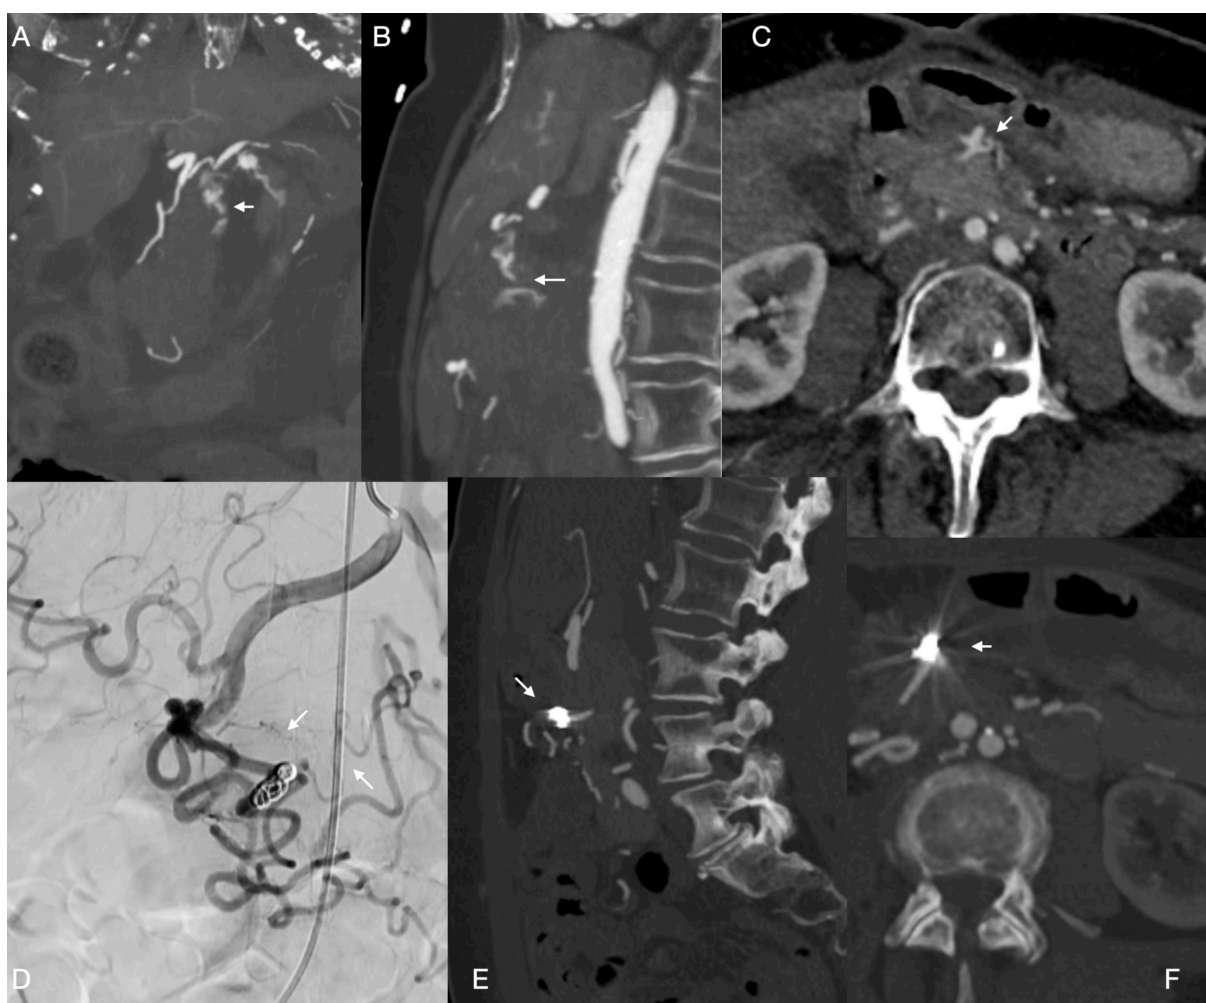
A) and B) CT axial and sagittal with active bleeding from gastro-duodenal artery - Arrowheads. C) Persistent aneurysm verum after bleeding from cranially located branch of gastro-duodenal artery Arrowhead. D) Angiographic control of gastro-duodenal artery with patent collaterals after coiling of aneurysm. Arrows. E) and F) CT-control after successful coiling. Arrowheads.
